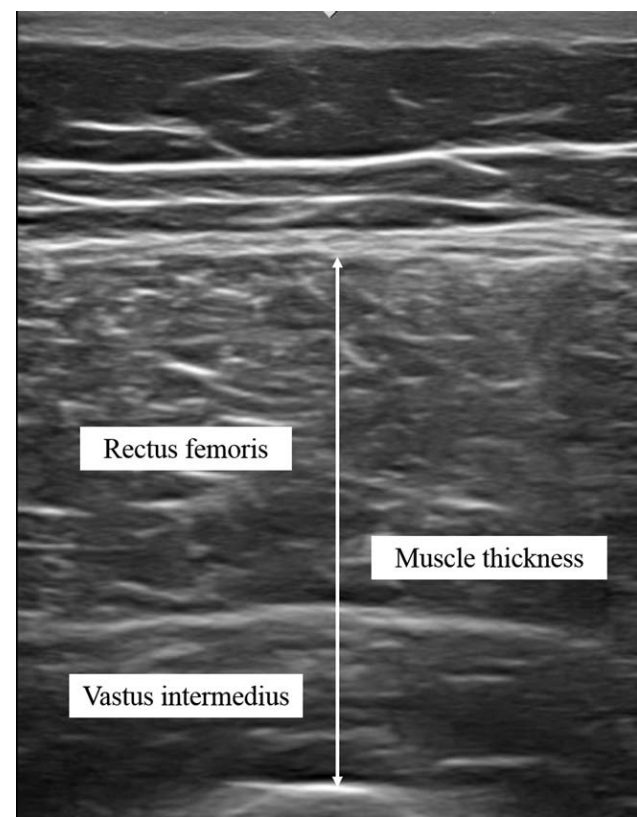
A representative ultrasound image of quadriceps femoris muscle.
